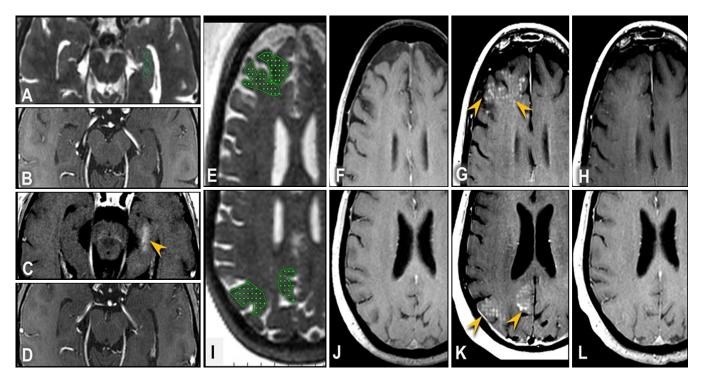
MRI evidence of BBB opening and closure in the hippocampus, frontal lobe, and parietal lobe. A: Axial T2-weighted MR image shows 3 target sites (*green circles*) in the left hippocampus. B–D: Baseline (B), immediate post-FUS (C), and 24 hours post-FUS (D) contrast-enhanced axial T1-weighted MR images show parenchymal contrast enhancement at targeted hippocampal sites (*arrowhead*, C), indicating BBB opening and resolution of enhancement at 24 hours following repeat contrast administration, indicative of BBB closure. E: Axial T2-weighted MR image shows target sites (*green dots*) in the right frontal lobe. F–H: Baseline (F), immediate post-FUS (G), and 24 hours post-FUS (H) contrast-enhanced axial T1-weighted MR images show parenchymal contrast enhancement at targeted right frontal lobe sites (*arrowheads*, G), indicating BBB opening, and resolution of enhancement at 24 hours following repeat contrast administration, indicative of BBB closure. I: Axial T2-weighted MR image shows target sites (*green dots*) in the right parietal lobe. J–L: Baseline (J), immediate post-FUS (K), and 24 hours post-FUS (L) contrast-enhanced axial T1-weighted MR images show parenchymal contrast enhancement at targeted right parietal lobe. J–L: Baseline (J), immediate post-FUS (K), and 24 hours post-FUS (L) contrast-enhanced axial T1-weighted MR images show parenchymal contrast enhancement at targeted right parietal lobe. J–L: Baseline (J), immediate post-FUS (K), and 24 hours post-FUS (L) contrast-enhanced axial T1-weighted MR images show parenchymal contrast enhancement at targeted right parietal lobe sites (*arrowheads*, K), indicating BBB opening, and resolution of enhancement at 24 hours following repeat contrast enhanced axial T1-weighted MR images show parenchymal contrast enhancement at targeted right parietal lobe sites (*arrowheads*, K), indicating BBB opening, and resolution of enhancement at 24 hours following repeat contrast enhanced axial T1-weighted MR images for the repeter endots) in the right parietal lobe. J–
